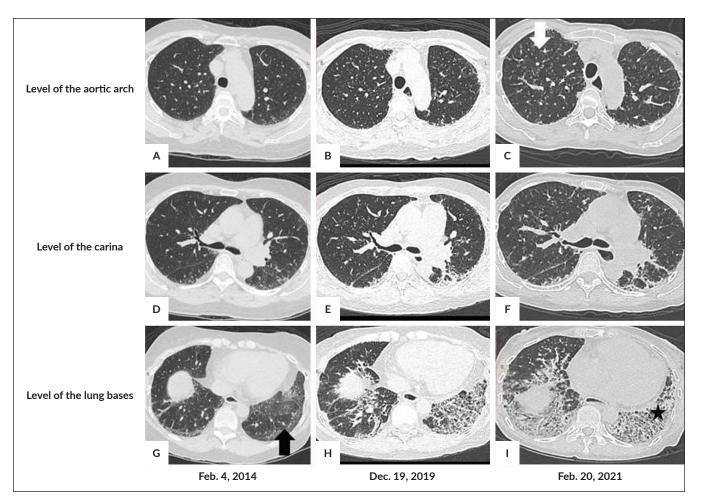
Axial sections of HRCT scans dated February 4, 2014, December 19, 2019, and February 20, 2021, were taken at the levels of the aortic arch (A-C), carinal bifurcation (D-F), and lung bases (G-I). These images show interval progression of reticulonodular opacities (*white arrow*) in both lungs. Septal thickening, predominantly in the lung bases (*black arrow*), is observed in the first imaging study, with progression in both lungs and assuming a "honeycomb" appearance (*black star*), in the succeeding studies. Traction bronchiectasis, subpleural bands, and multiple fibrosis are likewise noted.
